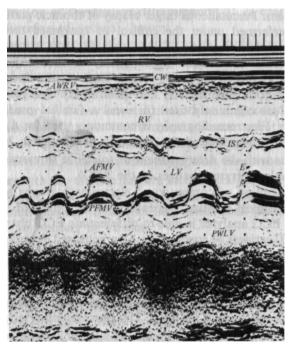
Echocardiogram of the anterior flap of the mitral valve in mitral stenosis. CW—chest wall; AWRV—anterior wall of the right ventricle; RV—right ventricle; IS—interventricular septum; LV—left ventricle; AFMV—anterior flap of the mitral valve; PFMV—posterior flap of the mitral valve; PWLV—posterior wall of the left ventricle.
